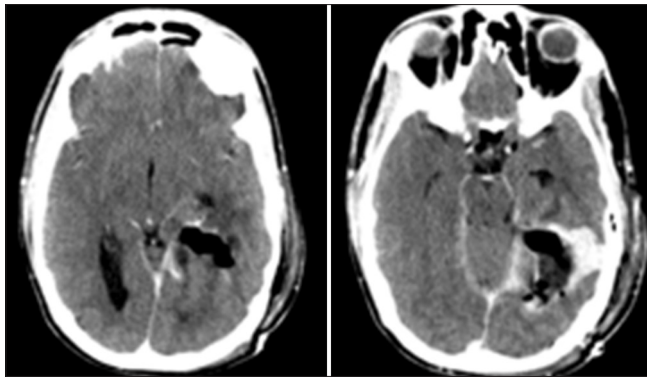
Postoperative axial CT-scan with contrast after a partial resection of the tumor through a supracerebellar-transtentorial approach
